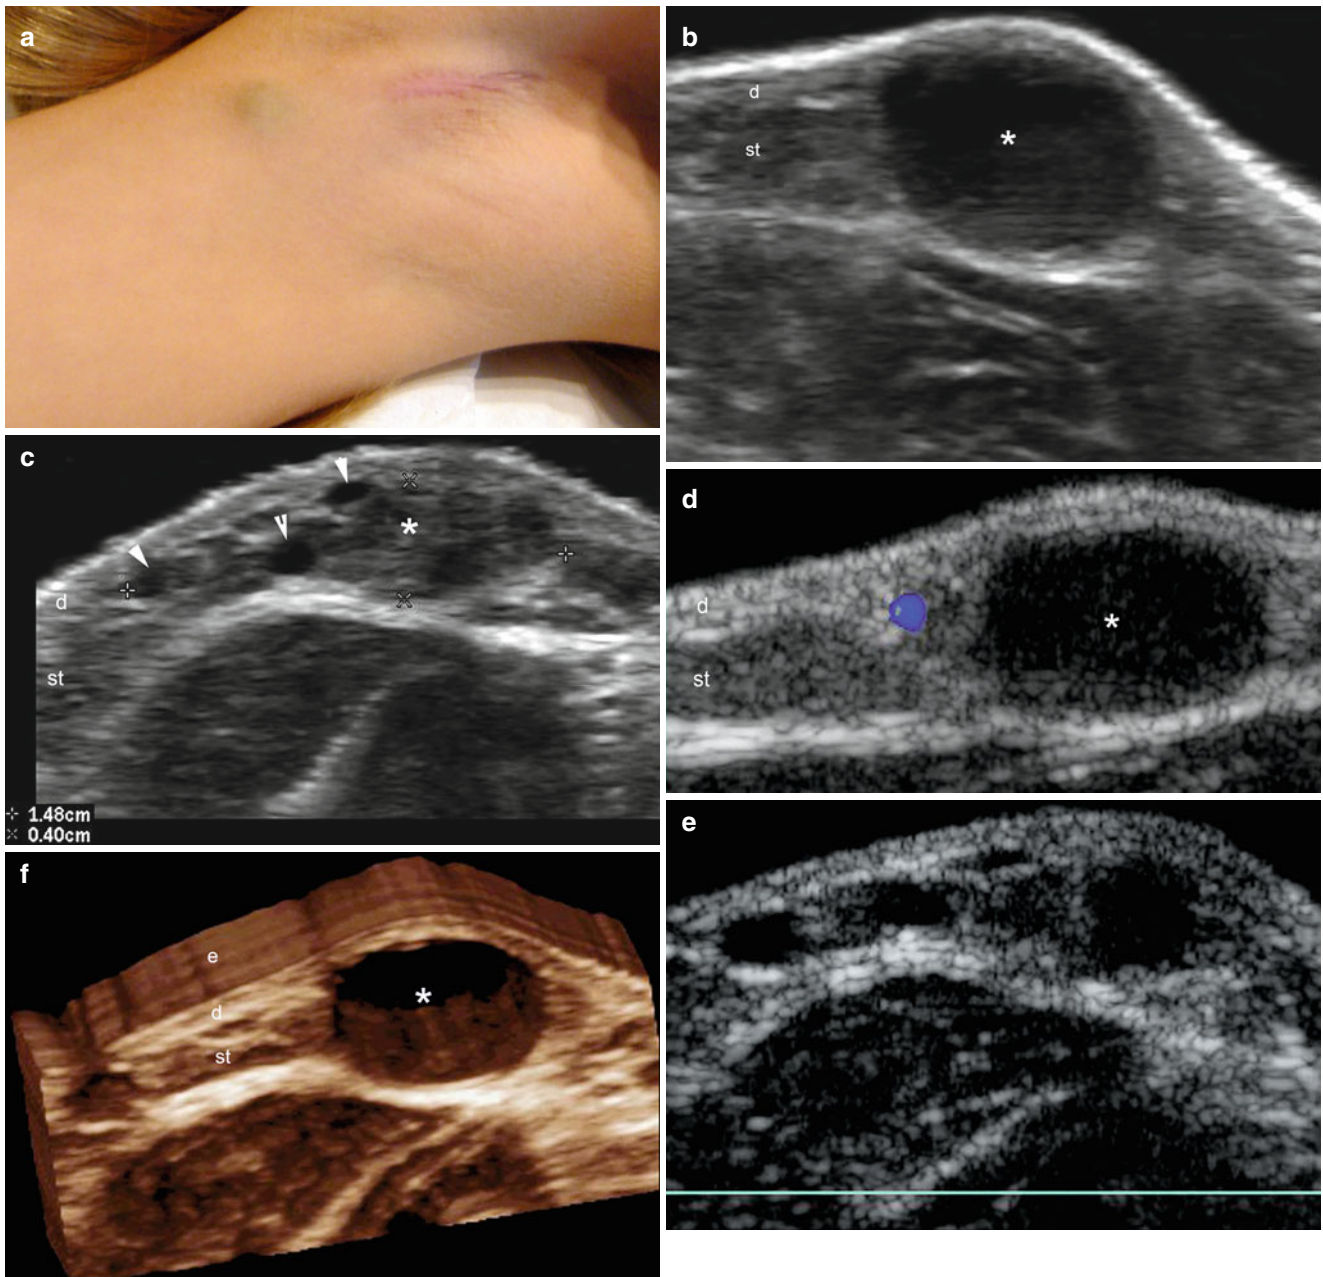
(a–f) Low-flow lymphatic vascular malformation. (a) Clinical image shows a lesion with swelling in the inner aspect of the right arm. Notice the erythematous scar in the axilla secondary to a previous partial removal of the lymphatic malformation. (b, c) Grey scale ultrasound images (transverse view) demonstrate multiple well-defined round-shaped anechoic pseudocystic structures in the dermis
